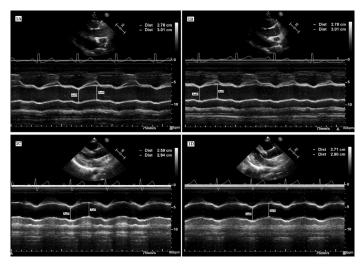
Systolic and diastolic diameter measurements of the ascending aorta with M-mode echocardiography. Before (1A) and after (1B) sublingual administration of nitroglycerin, there was no change in pulsatile diameter change in a CAD patient. Before (1C) and after (1D) sublingual administration of nitroglycerin, there was a prominent decrease in pulsatile diameter change in a non-CAD patient after nitroglycerin. AoS: Aortic systolic diameter, AoD: Aortic diastolic diameter
